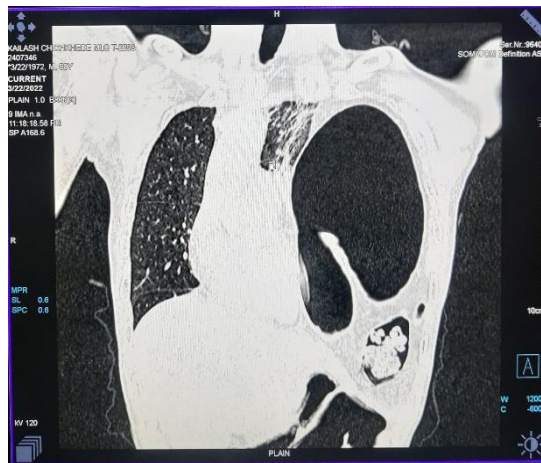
CT section showing herniation of Stomach folded on itself in left hemithorax on left side
